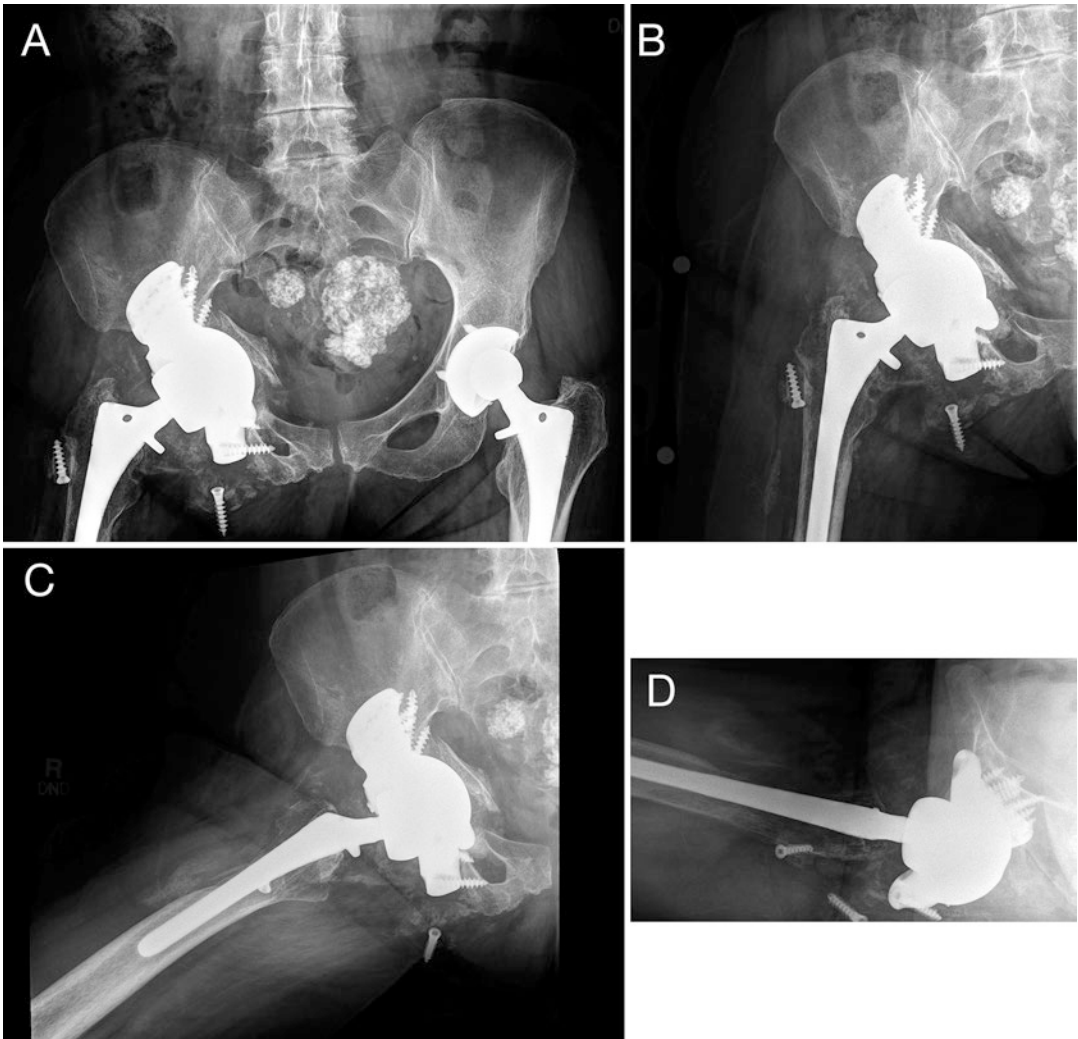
(a) Anteroposterior (AP) pelvic, (b) AP hip, (c) oblique, and (d) cross-table lateral radiographs of the above patient at 2 years of follow-up. *Images courtesy of Michael J. Taunton, M.D.*
